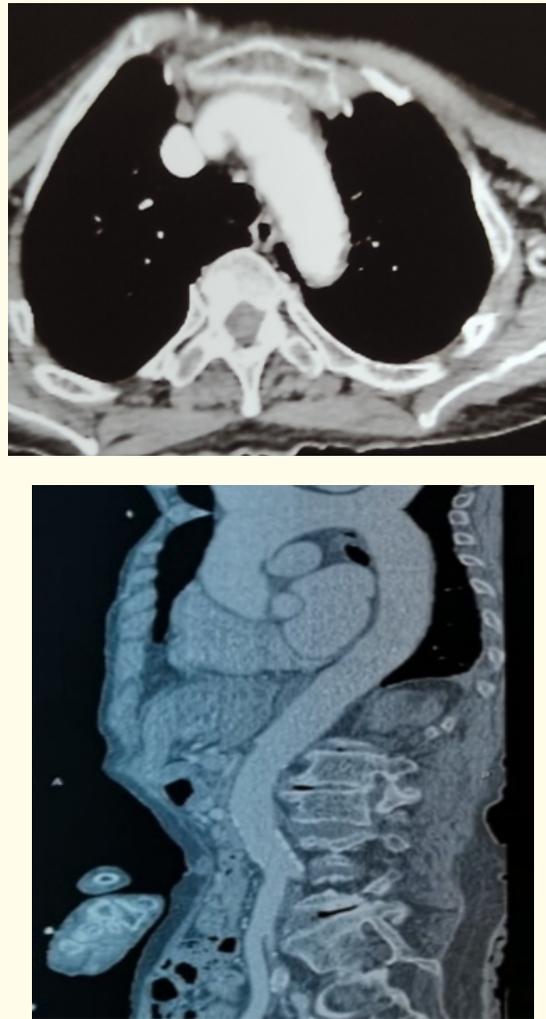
Axial and sagittal thoracic CT images demonstrating a saccular aneurysm of the sinus of valsalva associated to a penetrating aortic ulcer.
